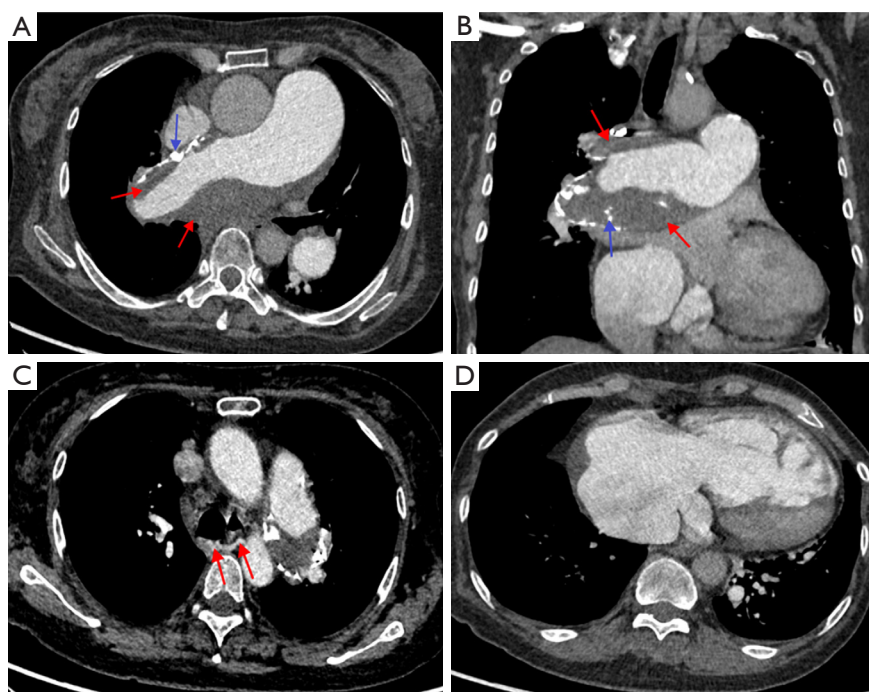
A 59-year-old woman with a pathological diagnosis of chronic pulmonary thromboembolism. (A,B) CTPA axial and coronal images showed eccentric filling defects attached to the right pulmonary artery wall (red arrows), calcification within the lesion and on the pulmonary artery wall (blue arrows), and dilatation of the main pulmonary artery. (C) CTPA axial imaging showed collateral circulation in the mediastinum (red arrows). (D) A significantly dilated right atrium and ventricle suggested right heart dysfunction. CTPA, computed tomography pulmonary angiography.
